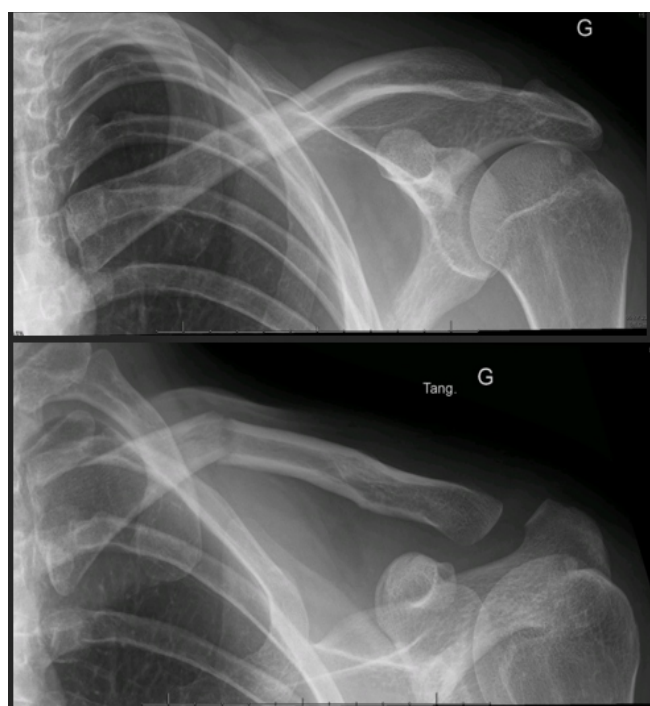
Radiograph taken at the first consultation, 1 week after the accident.
